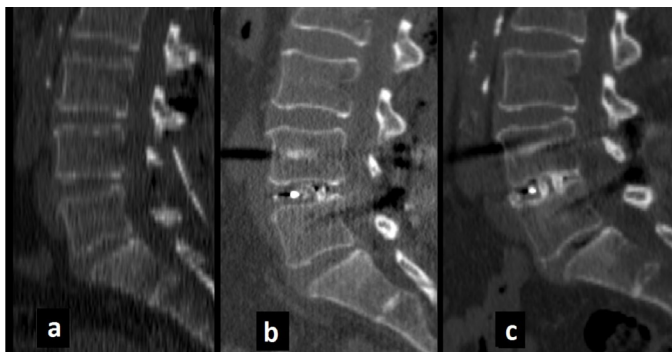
In the case of interbody cage; a (preoperative), b (early postoperative), c (late postoperative) sagittal CT reconstruction
